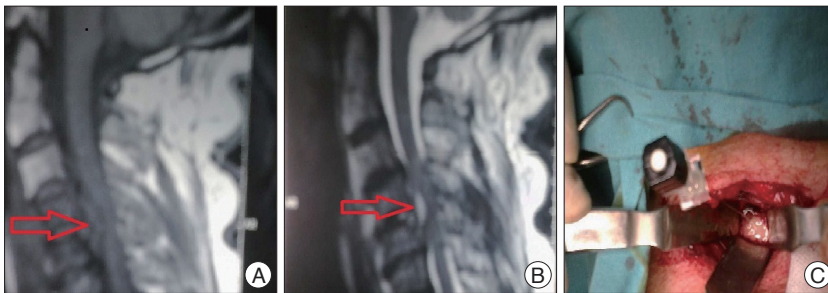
A : Sagittal T1 weighted magnetic resonance imaging (MRI) of Case1 revealing spinal cord compression at the C4-5 disc level (arrow). B : Sagittal T2 weighted MRI of Case 1 revealing hyperintense epidural lesion and spinal cord compression at C4-5 disc level (arrow). C : The abscess is seen intraoperatively after insertion of needle into C4-5 disc space.
